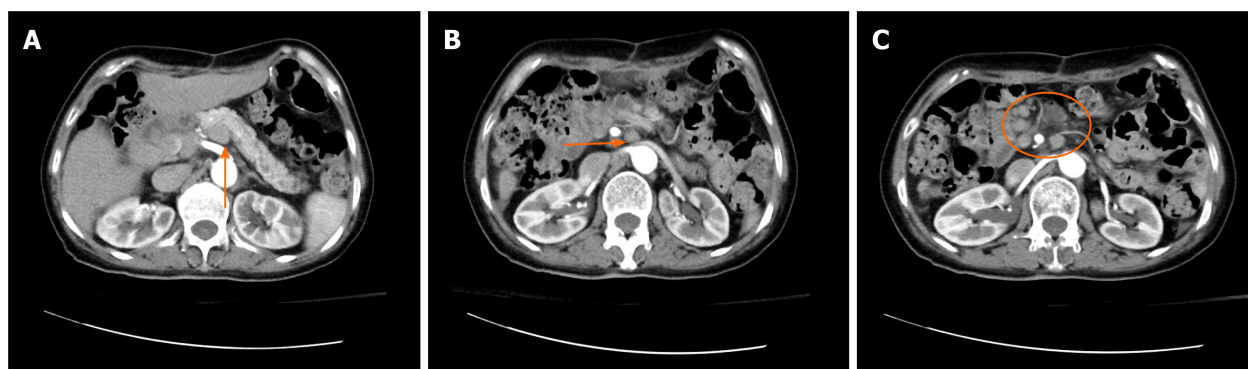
Contrast-enhanced computed tomography scan of the whole abdomen. Multiple enlarged lymph nodes in the retroperitoneum and porta hepatis region and no obvious enhancement, which suggested a metastatic tumor. A: Retroperitoneum (orange arrow); B and C: Porta hepatis region (shown by orange arrows and orange circles).
